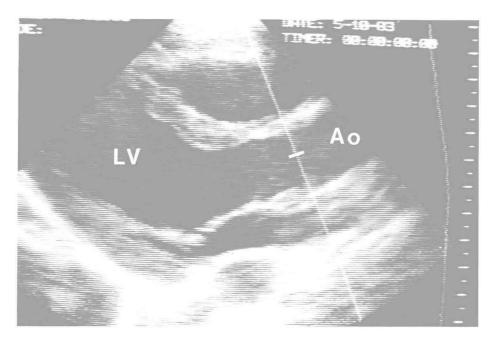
Duplex pulsed Doppler systems combine a B-scan image with a cursor, permitting directional and depth indicators of the position of the pulse Doppler sample. The figure shows a long axis view of the heart, displaying the left ventricle (LV) and aorta (AO). The Doppler sample volume can be selected along a directable cursor line at an adjustable depth (white bar). Here the sample is taken from the ascending aorta just above the aortic valve.
